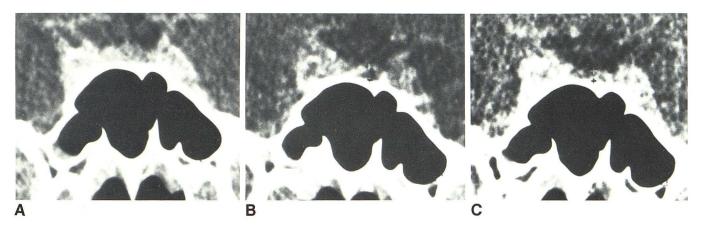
Case 7. Mild degree of progressive pituitary atrophy. A, First CT (normal pituitary). B, Second CT (mild atrophy). C, Third CT (mild atrophy). Round low density within enhanced sellar area on B is an artifact.
